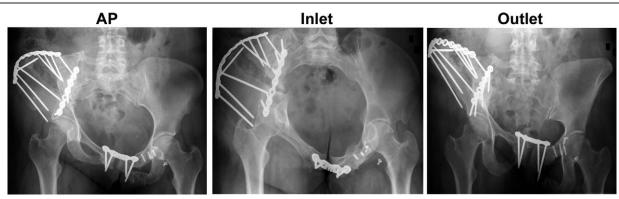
Postoperative radiographs indicating a reduction in limb leg discrepancy, as well as in the vertical, anterior–posterior (AP), and rotational displacement, as compared with the preoperative radiographs.
